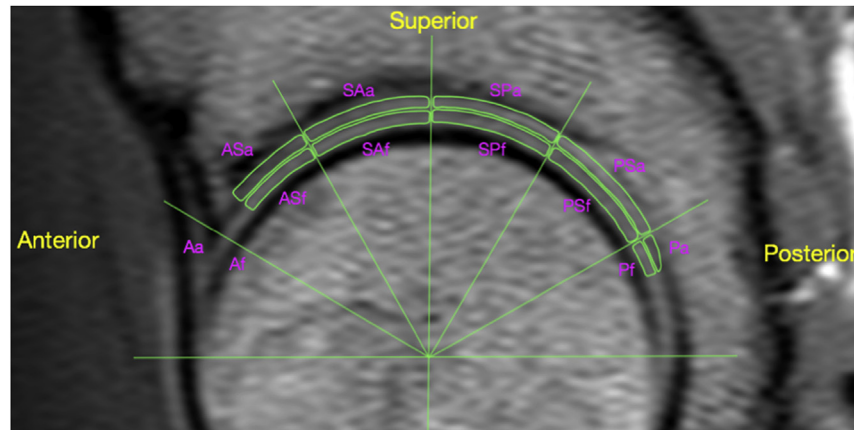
Regions of interest (ROI) for MRI segmentation.
